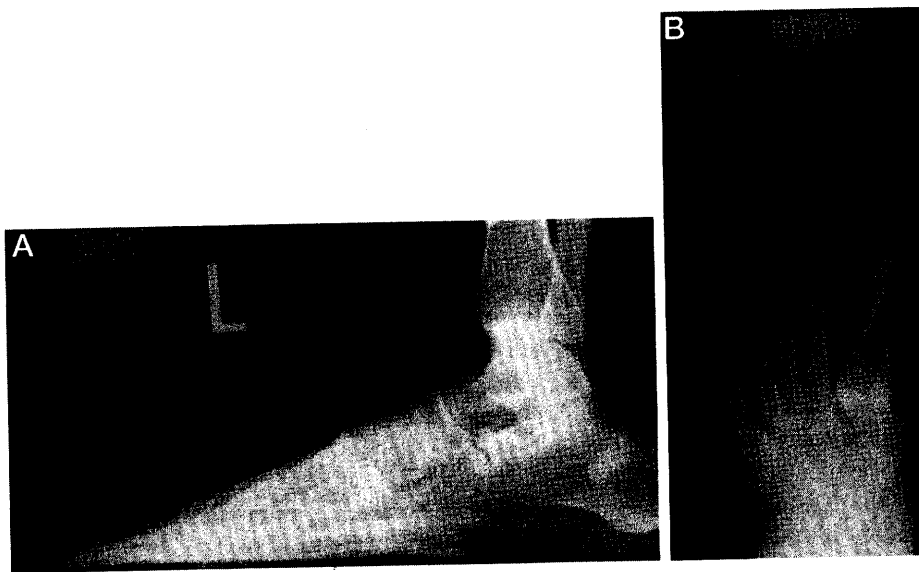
A, Lateral radiograph of left foot 1.5 years postoperatively. Incorporation of graft into fusion site shows further integration and reorganization. First metatarsal still shows mild to moderate elevation radiographically. B, Anterior-posterior radiograph of left foot 1.5 years postoperatively. Note the graft incorporation progression. The step-off of the medial cuneiform is still evident but this has not affected the patient clinically.
